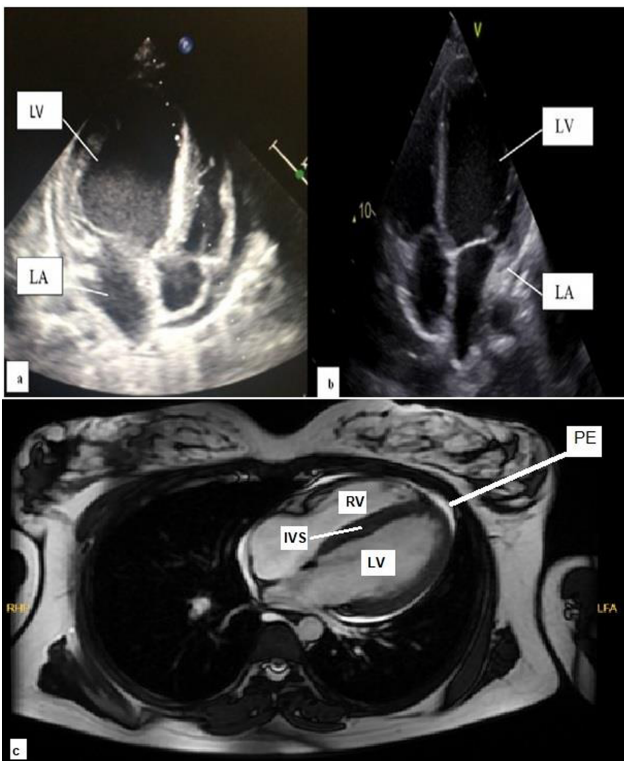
Echocardiographic images of the case 1 before treatment with bromocriptine (a) and two weeks after bromocriptine treatment (b), cardiac MRI image of the case 2 (c). (LA: left atrium, LV: left ventricle, RV: right ventricle, IVS: interventricular
